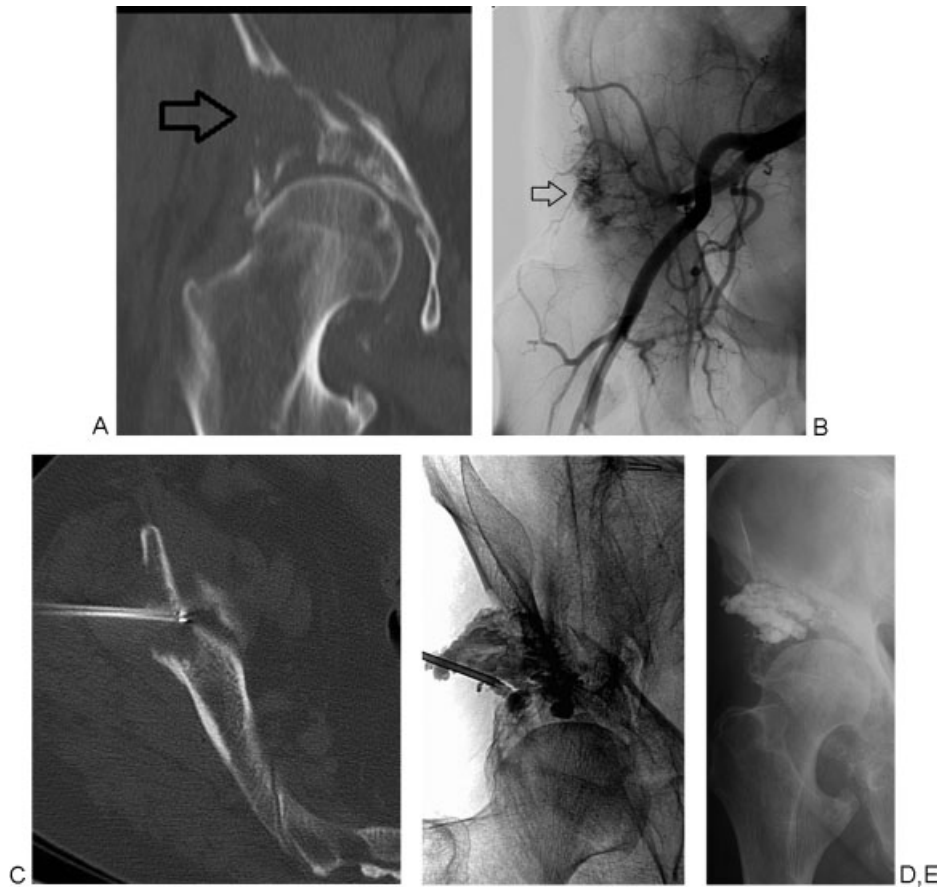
Multimodality treatment in 65-year-old nonambulatory man with metastatic renal cell cancer and severe right hip pain. (A) Coronal reconstruction CT scan demonstrates an acetabular osteolytic lesion and intra-articular fracture (arrow). (B) Preembolization angiogram demonstrating a hypervascular lesion (arrow) treated with particle embolization. (C) The patient suffered recurrent pain, and subsequent bone RFA was performed along the superior aspect of the lesion. (D) Cementoplasty augmentation after RFA was performed in to stabilize the joint. (E) Six-month posttreatment plain film; the patient's pain resolved and he was able to walk. CT, computed tomography; RFA, radiofrequency ablation.
